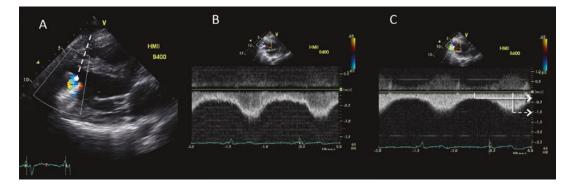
After LVAD implantation, (a) TEE shows that the inflow cannula is somewhat directed toward the ventricular septum (*arrow*). This can be acceptable but may predispose to inflow-cannula obstruction after sternal closure or later reduction in LV size. However, cannula position and flow velocities are shown to be acceptable (*normal*) in this case. Simultaneous orthogonal plane imaging reveals unobstructed, laminar inflow-cannula flow on 2D and color-flow Doppler (*blue*) examination. (b)
